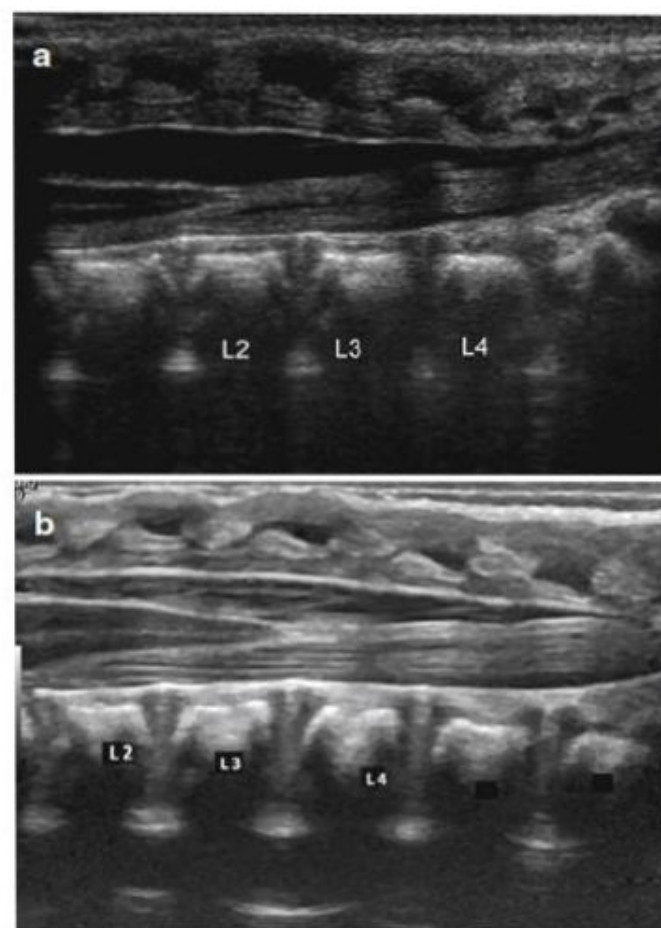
Spinal ultrasound of a newborn baby. (a) Normal. (b) Tethered cord
